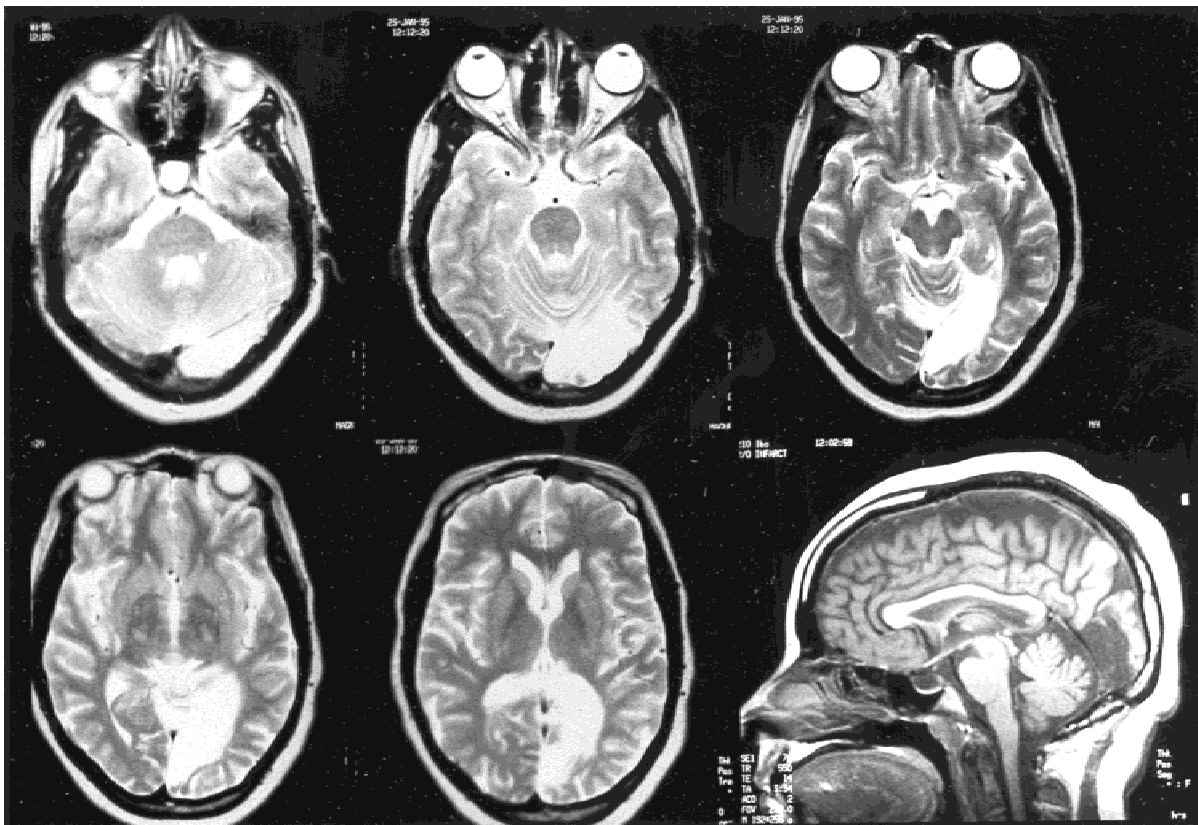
T2-weighted axial MR images and T1-weighted sagittal MR image of the brain for Patient V.T. Right side of the brain is seen on the left or axial images—sagittal image is of the left hemisphere. Infarction is seen in the territory of the left medial branch of the posterior cerebral artery (calcarine and parieto-occipital arteries). Infarction includes parts of Brodmann's areas 28, 31, and 18, and the left cerebellar hemisphere, as shown. Cortical areas of infarction include the lingual gyrus and parts of the fusiform gyrus and cuneus, and the retrosplenial area.
